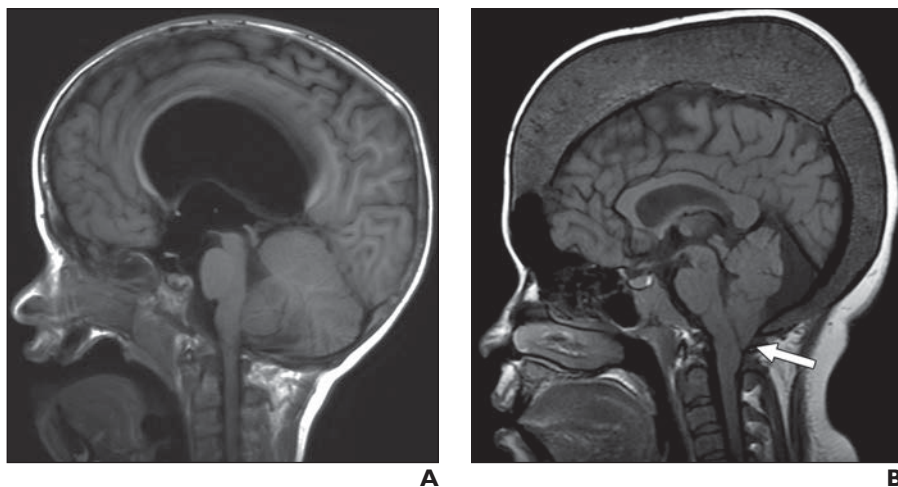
Osseous abnormalities. A, 17-year-old girl with thalassemia and long-standing progressive macrocephaly due to extramedullary hematopoiesis. Sagittal T1-weighted MR image shows marked calvarial thickening and secondary cerebellar tonsillar herniation. B, 6-year-old boy with achondroplasia. Sagittal T1-weighted MR image shows macrocephaly with frontal bossing and supratentorial hydrocephalus with effacement of CSF spaces around foramen magnum (arrow).
